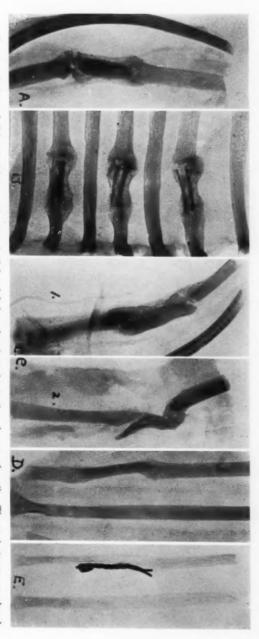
A. Auto-skull bone without periosteum, in defect left by subperiosteal resection of 2 cm. of a rib. The periosteum was closed. X-ray taken 35 days later. B. Sections of iso-rib without periosteum, in defects left by subperiosteal resection of 3 ribs. The periosteum was closed over each. X-ray taken 44 days later. C. Auto-bone shavings with blood in defect after subperiosteal resection of a rib. The periosteum was not closed in either experiment. X-ray taken (1) after 50 days; (2) after 94 days. D. Auto-fibula with its periosteum in the defect after subperiosteal resection of 2 cm. of a rib. The periosteum was closed over the transplant. X-ray taken 93 days later. E. A piece of twisted silver were was placed in the defect made by the subperiosteal resection of 2.4 cm. of a rib. The periosteum was closed over the wire. X-ray taken 206 days later.
